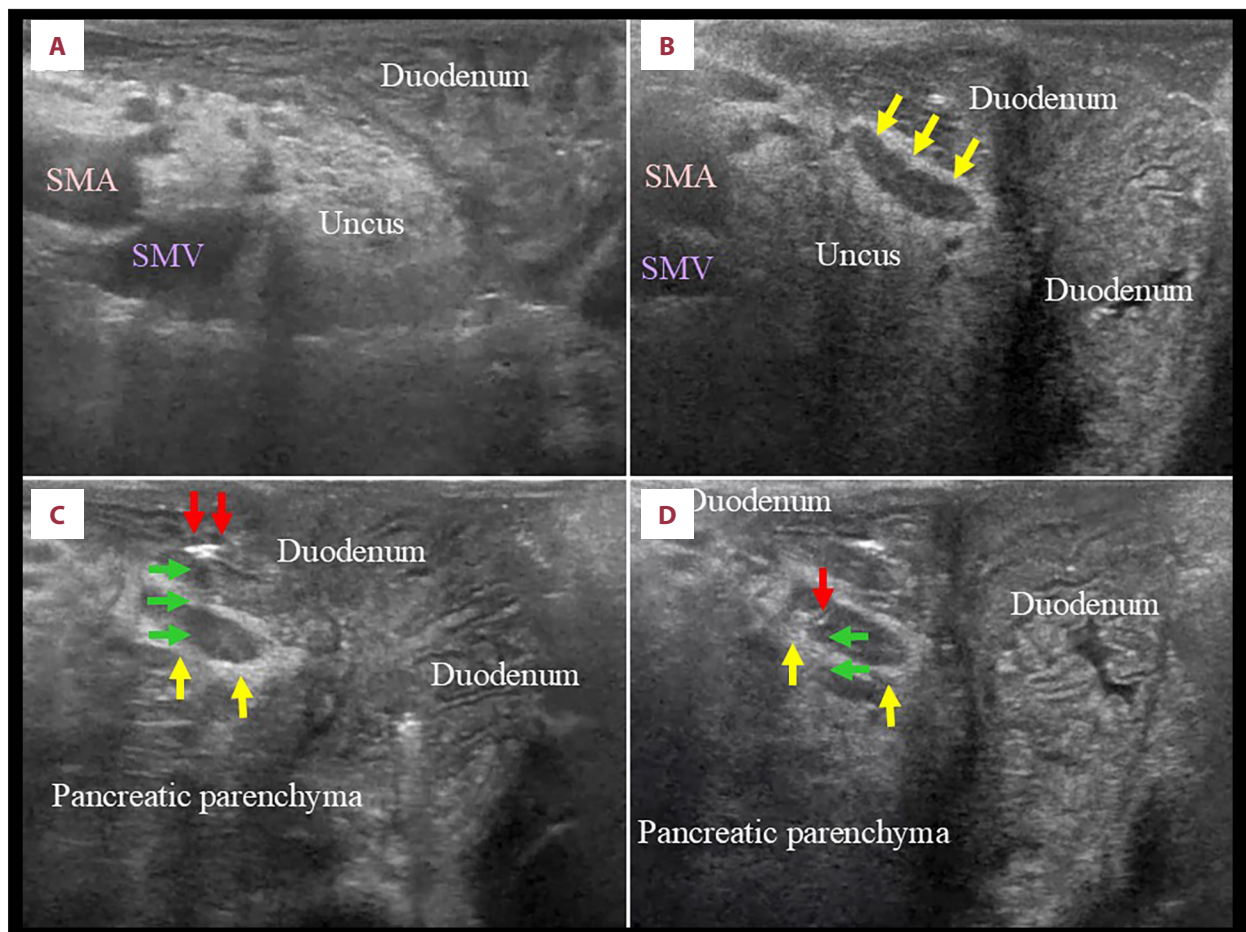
Intraoperative ultrasound findings. No foreign body within the pancreatic parenchyma of the uncus could be detected by intraoperative ultrasonography (A, B). During surgical mobilization, the migrated scad bone was displaced from the uncus and broken into 2 fragments. These fragments were located in the third portion of the duodenum (C) and within the diverticular cavity (yellow arrows) (D). Both fragments were recognized as highly echogenic lesions (yellow arrows) with acoustic shadows (green arrows) (C, D). SMA, superior mesenteric artery; SMV, superior mesenteric vein.
